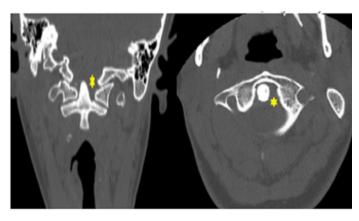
Cervical Spinal CT (atlantoaxial dislocation)
